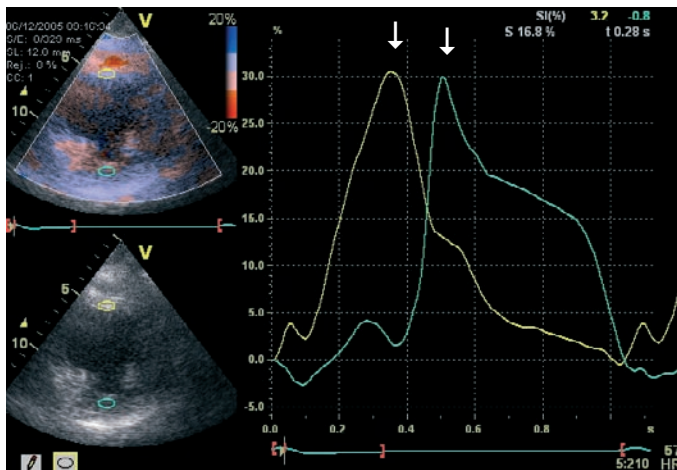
Example of tissue Doppler-derived radial strain imaging in the parasternal short axis view at the mid-LV level in a patient with severe LV dyssynchrony (160 ms). LV dyssynchrony is defined as the difference in peak strain between the antero-septum (yellow curve) and the posterior wall (green curve). (Arrows indicate peak strain)
